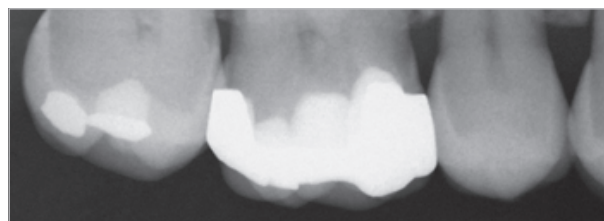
Bitewing radiograph (section of maxilla) revealing a 25-year-old, three-surface restoration of the maxillary right first molar in a 51-year-old woman. No signs of further proximal caries or increased attachment loss visible, thus indicating a low caries risk, along with an adequate oral hygiene.
